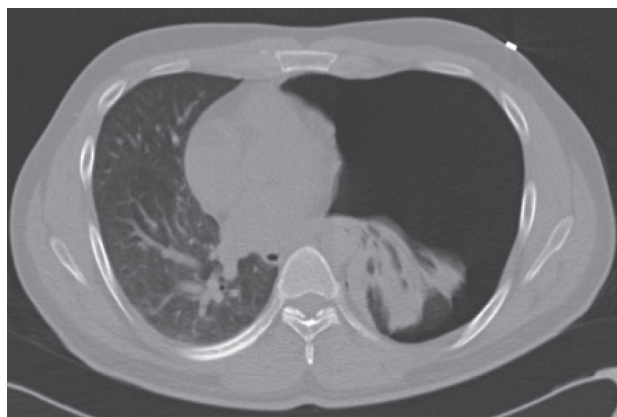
Computed Tomography thorax showing pneumothorax.
